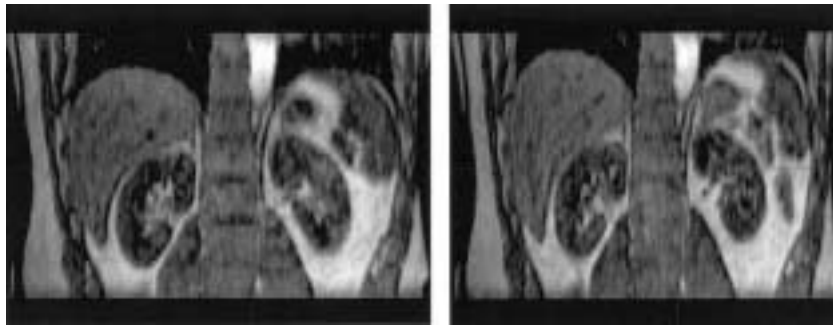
Cine MR images at inhale and exhale phases for a liver cancer patient.
